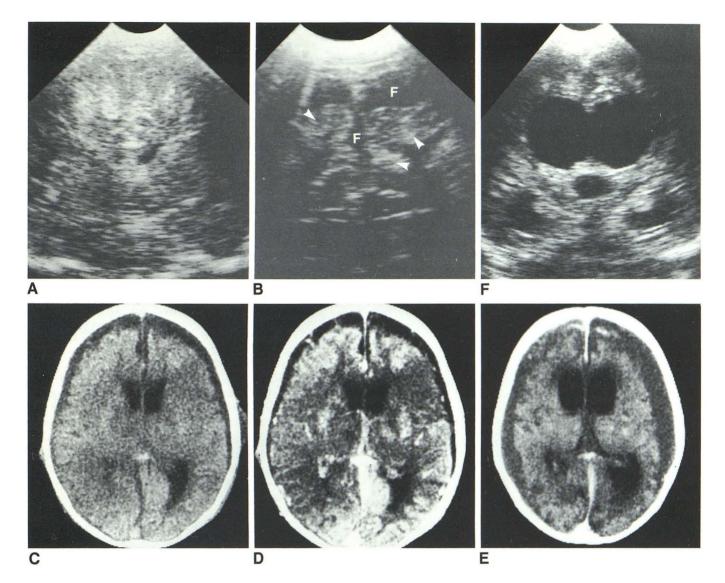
Case 2. A, Coronal sonogram with 5 MHz transducer. Abnormal brain parenchymal echogenicity. B, Magnified coronal sonogram with 7.5 MHz transducer. Moderate extraaxial fluid in interhemispheric fissure and over convexities (F) and increased gyral echoes (*arrowheads*). CT scans on day 9
